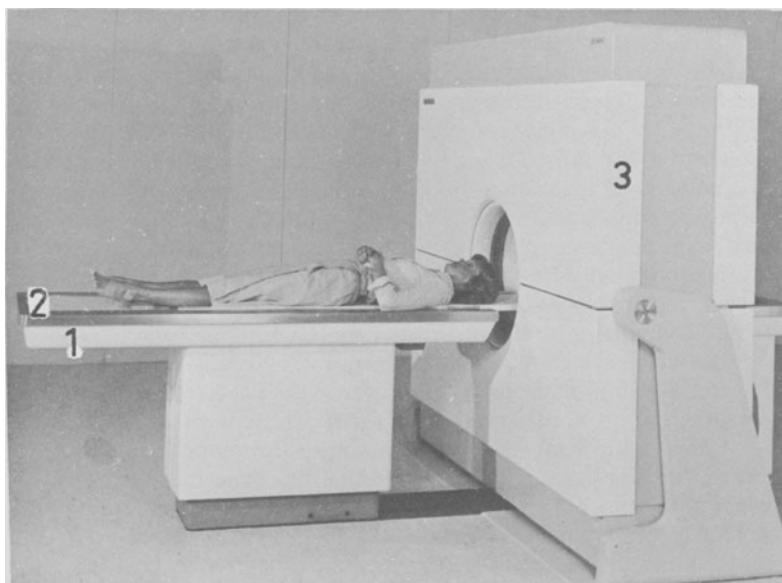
Stand for whole-body scanning. 1. Table-top on which 2 is located; 2. cradle on which the patient lies (this can be moved cranially in the opening up to the desired section); 3. shield in which the X-ray tube and detectors (which can be rotated) are housed.
